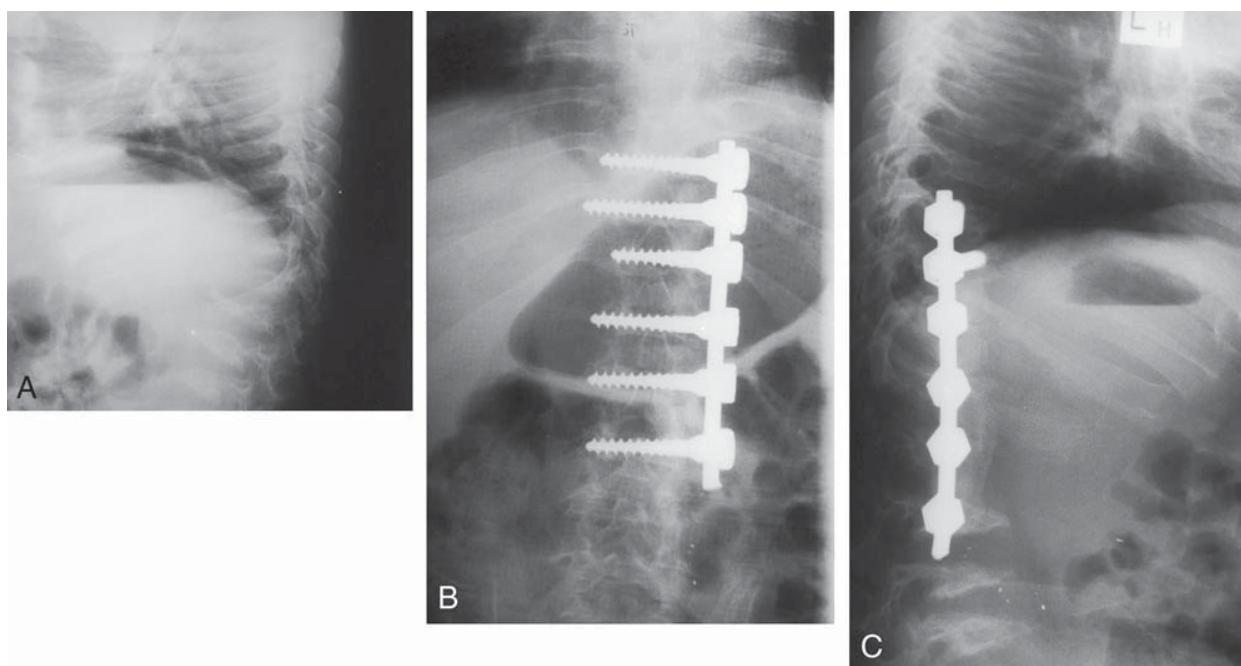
A, Preoperative radiographs of patient 1. B, Anteroposterior radiographs showing the instrumentation in place. C, Radiograph at 3 years, showing correction of the gibbus with the instrumentation and a solid bony fusion.
